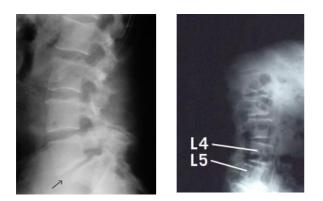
X-rays of spondylolisthesis.
